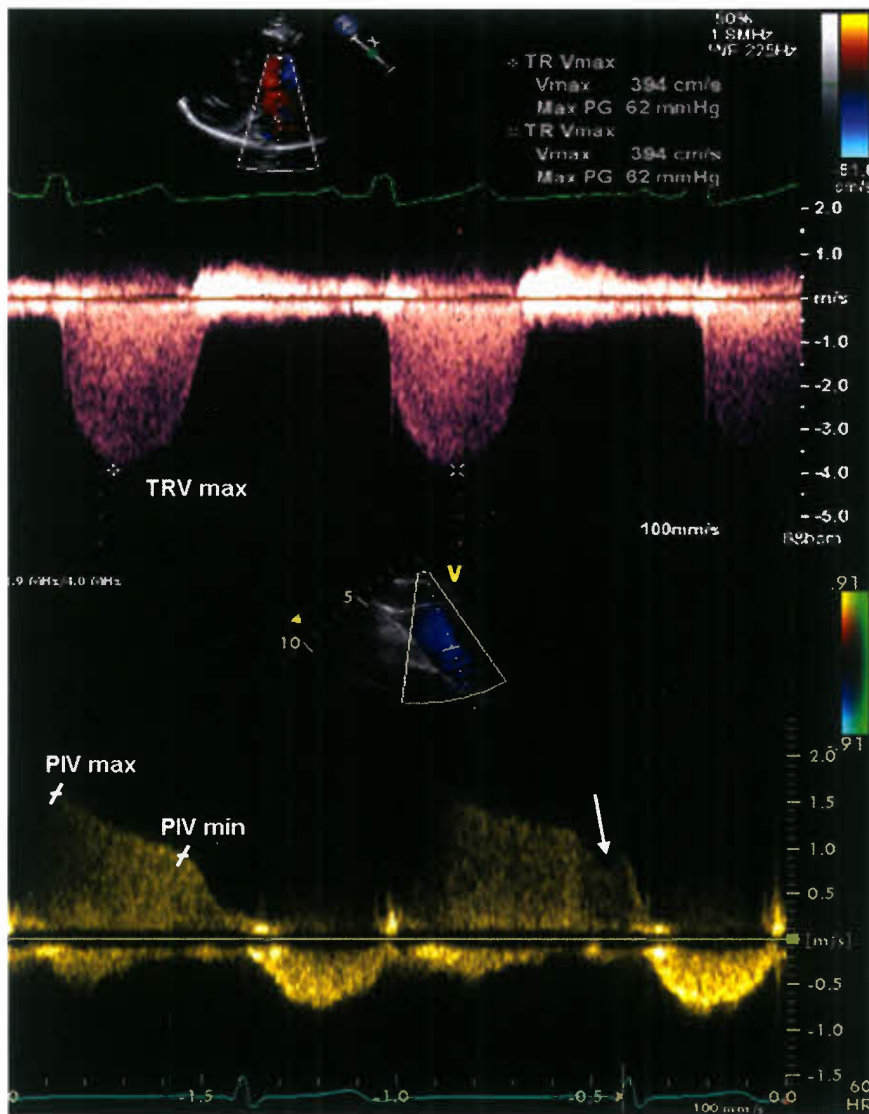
Echocardiographic evaluation of PH. Spectral Doppler images of TR, demonstrating an optimal Doppler envelope to obtain the maximal TR velocity (top image), and of pulmonary insufficiency (bottom image). The left marker represents the peak early diastolic velocity and the right marker represents the end diastolic velocity of the pulmonary insufficiency Doppler curve. The arrow represents the end-diastolic “shoulder” of the pulmonary insufficiency jet. V(TR) max, tricuspid regurgitation peak velocity; V(PR) max, pulmonary insufficiency peak velocity; v(PR) min, pulmonary insufficiency end-diastolic velocity. (From Tissot C, Ivy DD. Echocardiographic evaluation of pulmonary hypertension. In: Beghetti M, ed. *Pediatric Pulmonary Hypertension*. Munich, Germany: Elsevier Urban & Fischer; 2011, with permission.)
